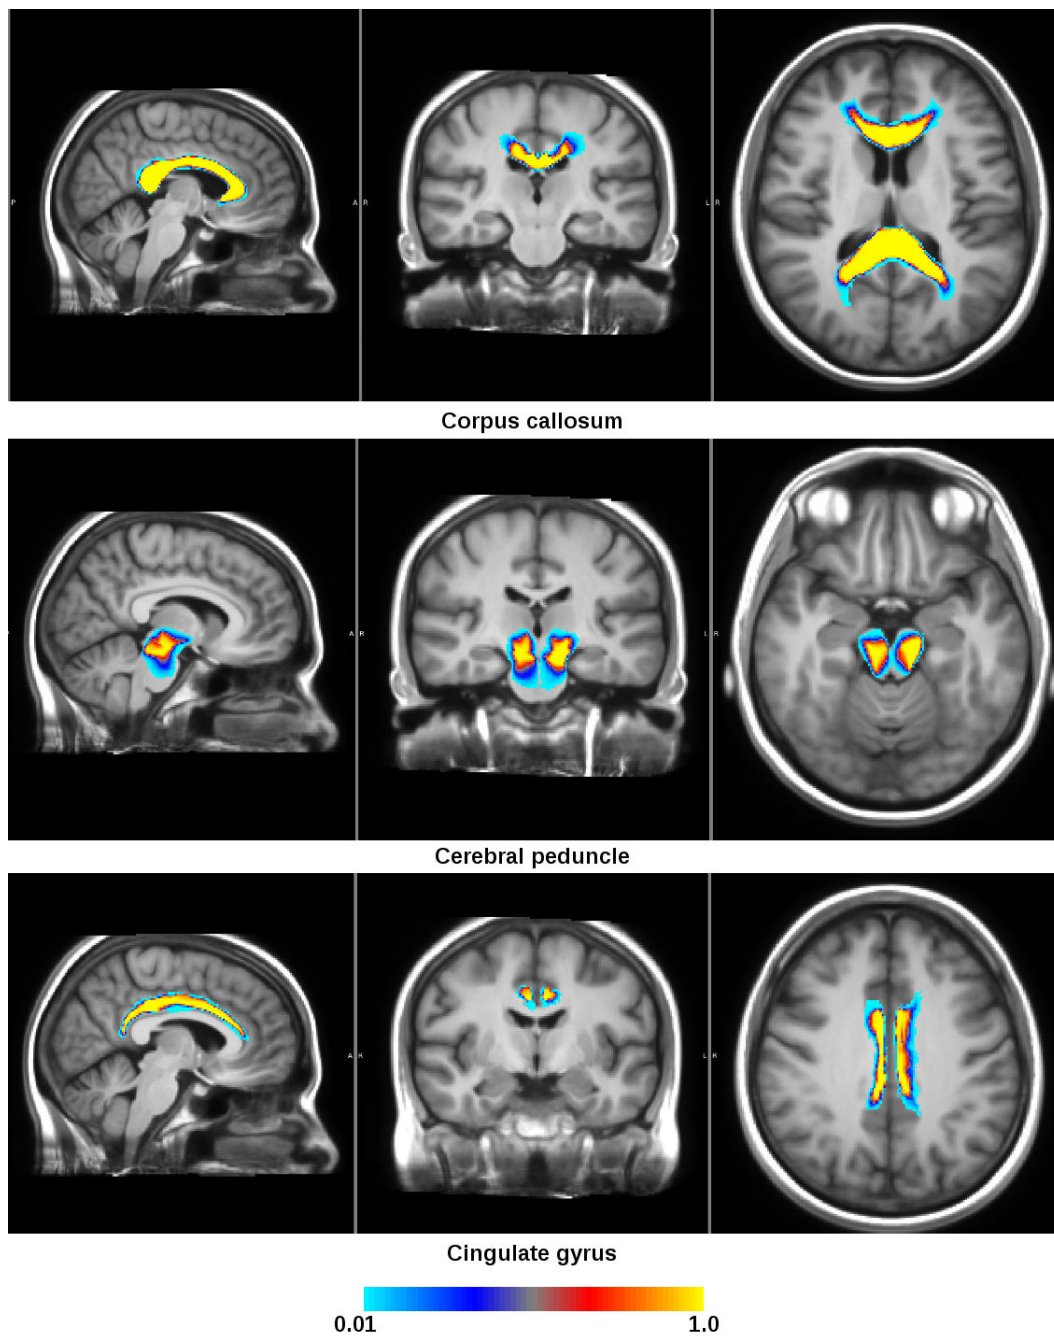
Regions of interest overlapped on the anatomical T1-weighted images (part 2)
